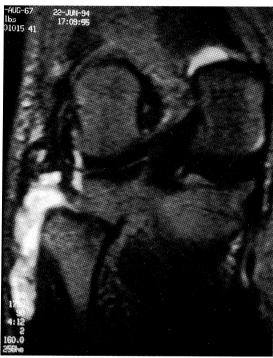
Patient with lateral collateral ligament (LCL) tear. Coronal spin-echo T2-weighted (TR 1750/TE 80) MR image of the right knee shows an ovoid predominantly high signal intensity fluid collection between the fibular head and the conjoint tendon. The collection is consistent with a haematoma in the lower LCL.
